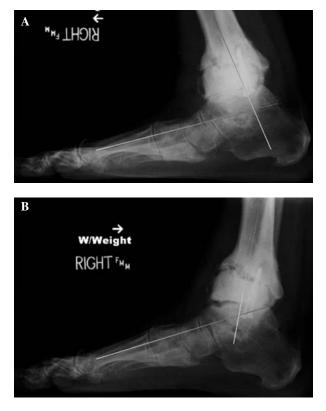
A, Ankle dorsiflexion X-ray with cement spacer in situ. B, Ankle plantarflexion X-ray with cement spacer in situ.
